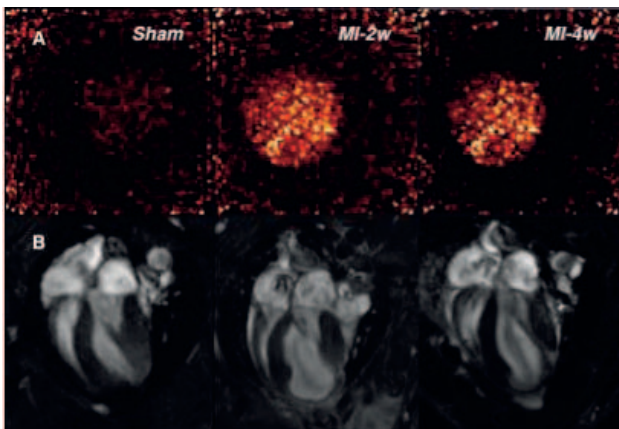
Ex vivo* nuclear imaging (µSPECT) and *in vivo* Cardiac Magnetic Resonance (CMR): A) *Ex vivo* ¹²³I-Galectin heart uptake and B) CMR for infarct size and functional heart analysis. MI-2W means 2-weeks-old-myocardial infarction and MI-4W, 4-weeks-old-myocardial infarction.
